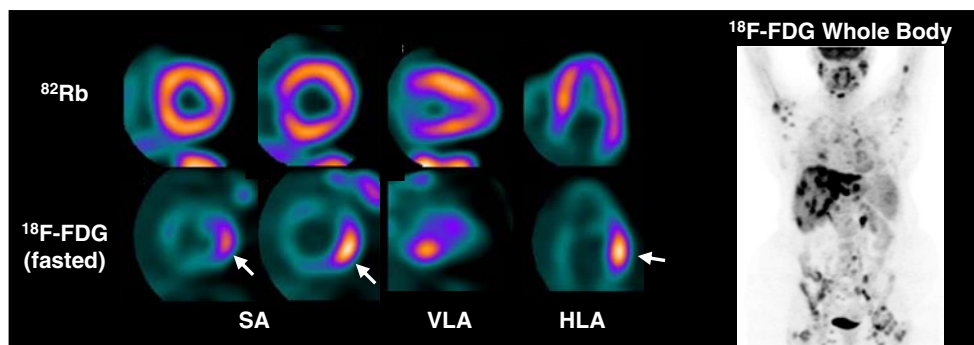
Resting perfusion and fasting ^{18}F -FDG images in a patient with sarcoidosis and ventricular tachycardia, with no evidence of CAD. Regional myocardial inflammation is identified in basal lateral wall (arrows), suggesting myocardial inflammation. ^{82}Rb uptake is
